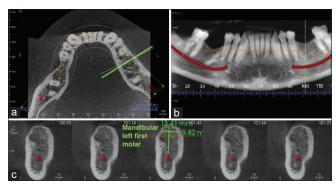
Edentulous ridge dimension measurements from reconstructed cone-beam computed tomography views. (a) Axial view; (b) Panoramic view; (c) Cross-sectional views. At the left mandibular first molar location, the ridge height was measured from the alveolar crest to the superior border of the mandibular canal. The ridge width was measured from the buccal to the lingual cortical plate approximately 2 mm below the alveolar crest
